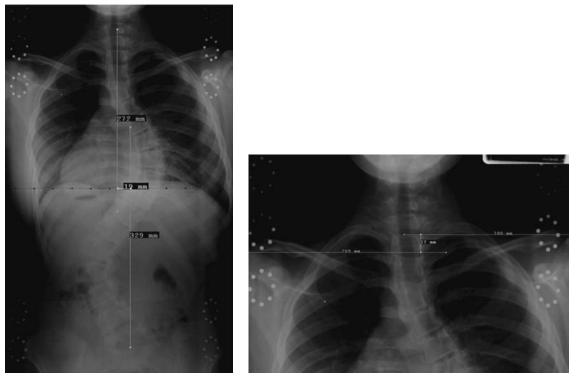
(A) Trunk-shape measure of coronal decompensation acquired via radiographs. (B) Trunk-shape measure of shoulder height acquired via radiographs.
